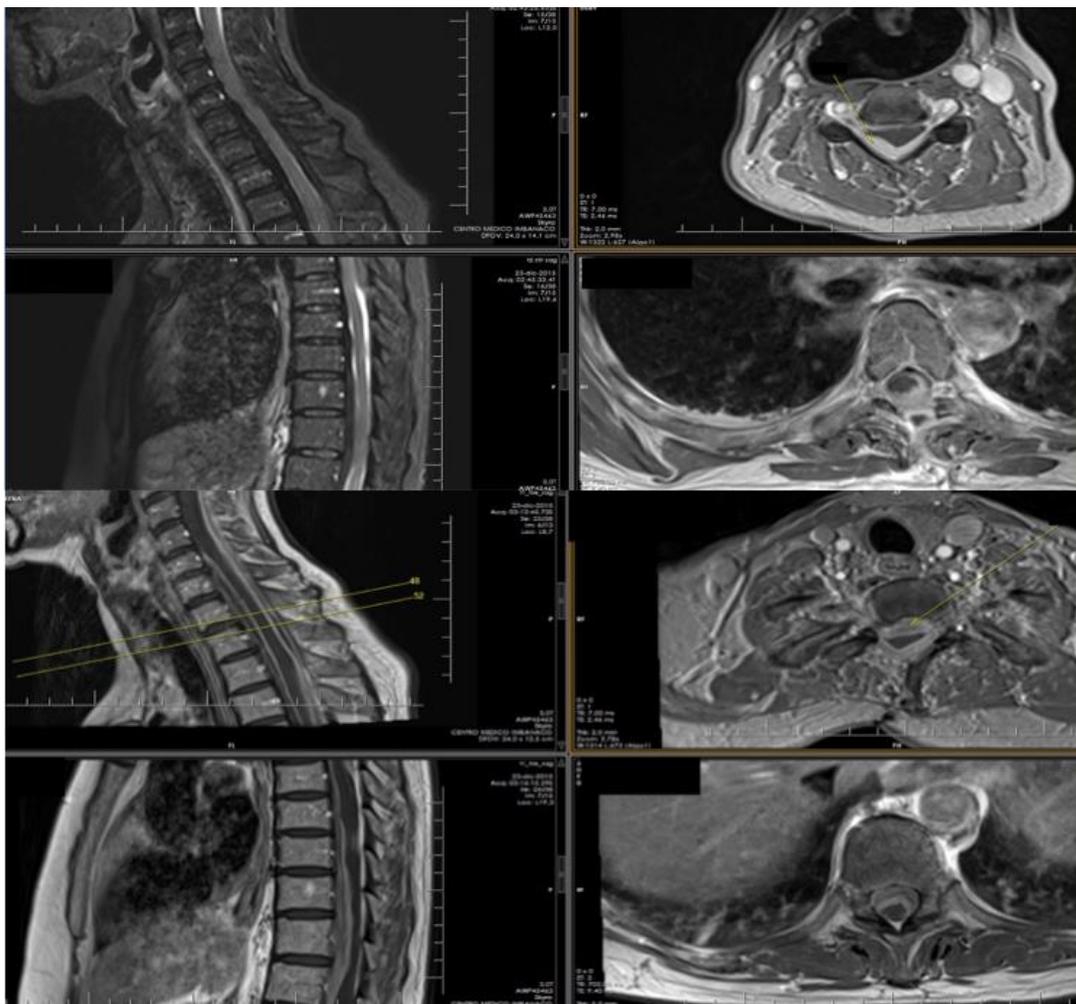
T2 weighted (upper images) MRI and with Gadolinium contrast medium (lower images) in relapse setting showing anterior and posterior compression of spinal cord.
